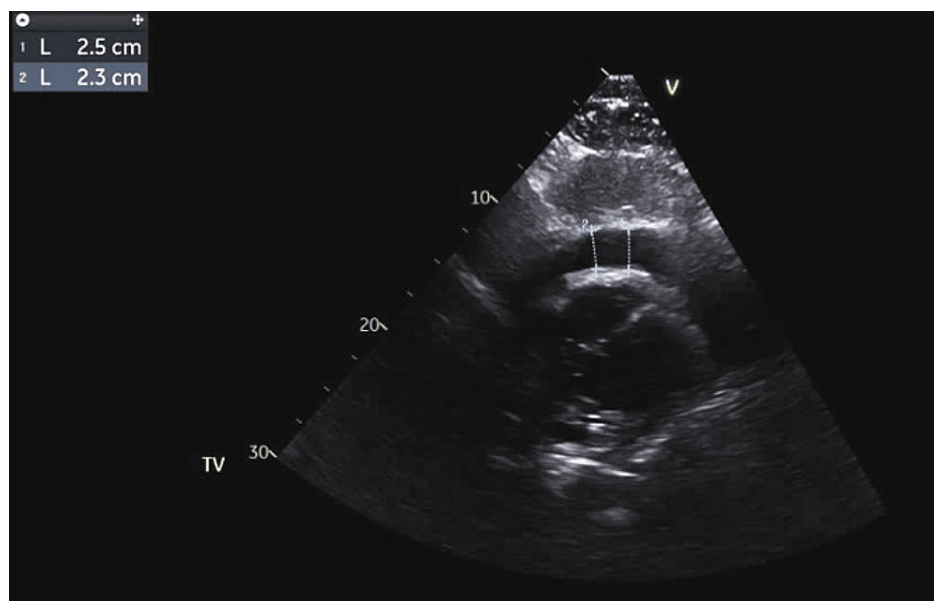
Transthoracic echocardiogram, parasternal short axis view, showing a large pericardial effusion measuring 2.5 cm (blue dotted lines).
